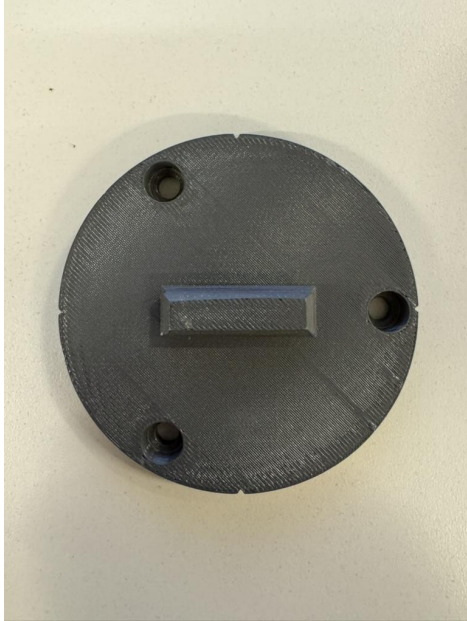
Platen attachment to Instron for applying load directly to the ultrasound probe.
